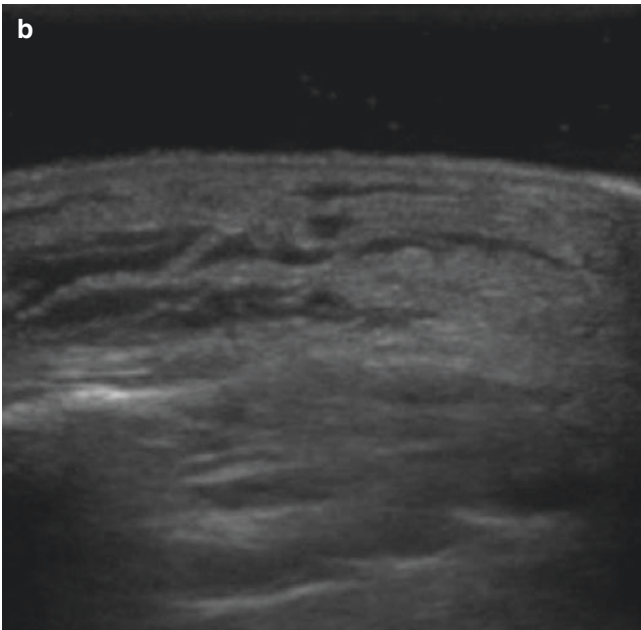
(a, b) The water bath technique uses water as a medium to conduct sound waves, similar to using gel during an examination. This is performed by immersing the extremity to be ultrasound under water. Consider using a water bath particularly when looking at hands and feet for abscess, cellulitis, foreign body, fracture, and evaluation of muscles and tendons. (a) Image courtesy of Errel Khordipour, (b) Image courtesy of Ee Tay
